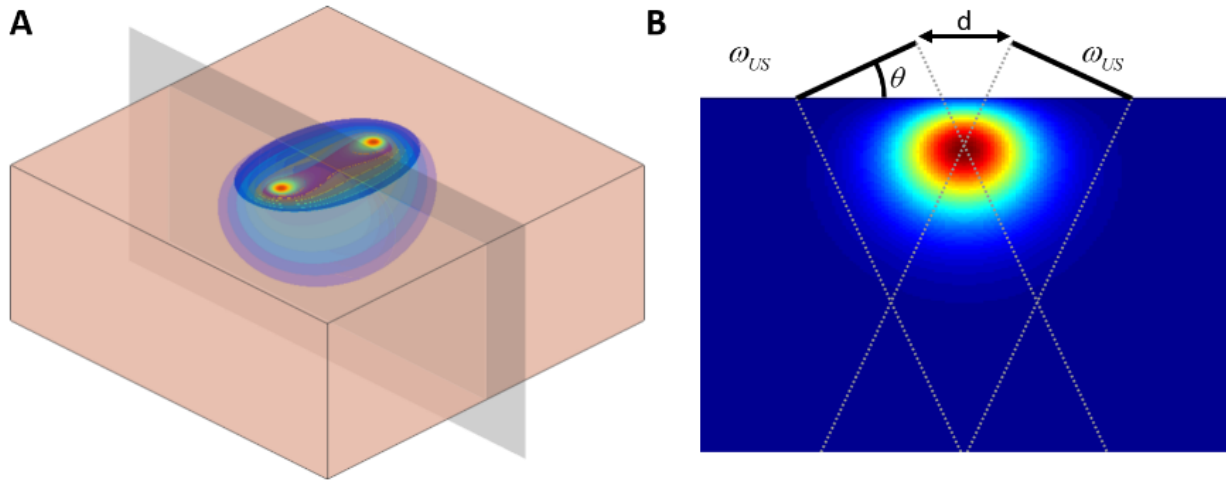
(A) Depiction of the sensitivity profile of DCS with a section plane at the midpoint between the source and detector, the cross section of which is shown in (B), showing the sensitivity of DCS overlaid with the projection of the two ultrasound elements
